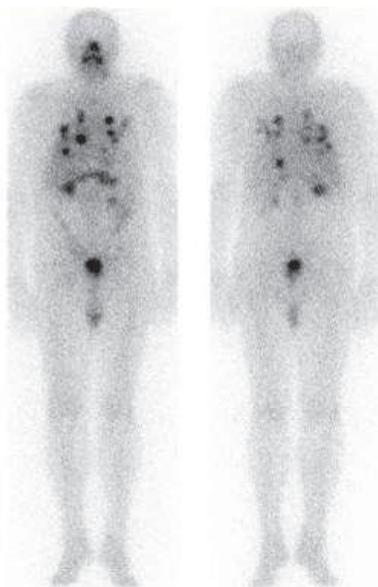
Post-therapy whole-body scintigraphy. Multiple lung metastases which accumulate radioiodine
